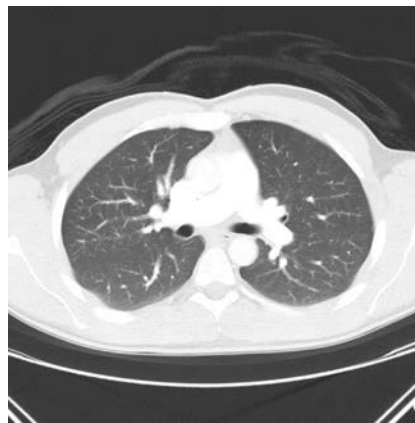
Axial CT of lung using lung windows preset.
